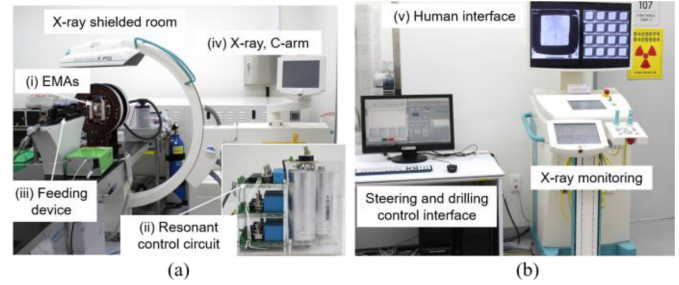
Overview of the GHM control system. (a) X-ray shielded room where the experiment is conducted, which includes the (i) EMA system for steering and drilling control of the GHM, (ii) resonant control circuit, (iii) feeding device, and (iv) C-arm X-ray imaging device. (b) Interface for user control of the EMA system and monitoring experiments.
